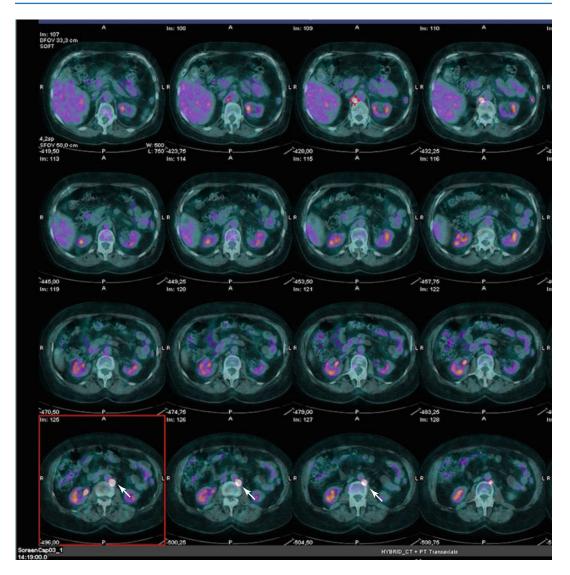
A 56-year-old female with ovarian cancer already treated by surgery and chemotherapy. Follow-up ¹⁸FDG PET/CT demonstrates a lumbo-aortic recurrent lymph node (*arrows*)
